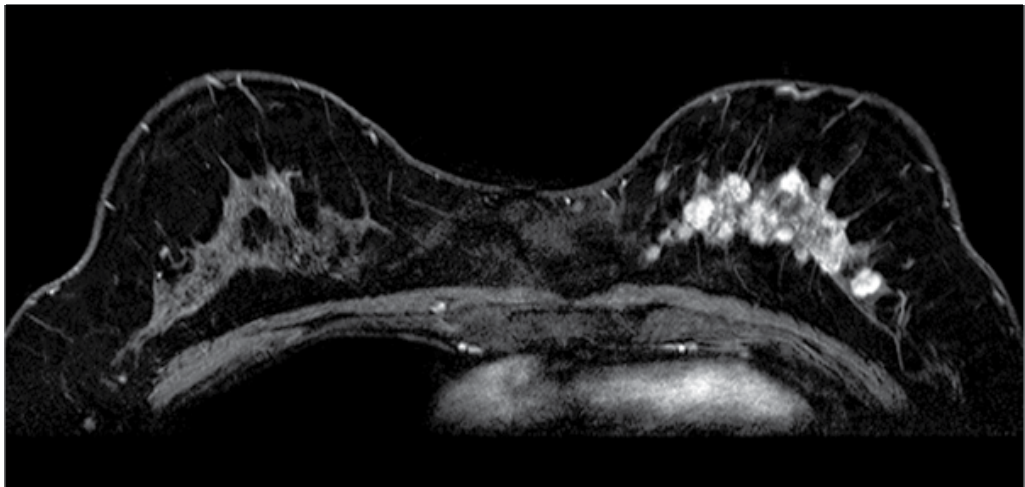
Contrast enhanced T1 weighted image on early phase of HR-MRI; Segmental distribution of multiple nodular mass-like enhancements are seen in the left breast. These mass-like enhancements might reflect the nodular growth of the secretory carcinoma.
